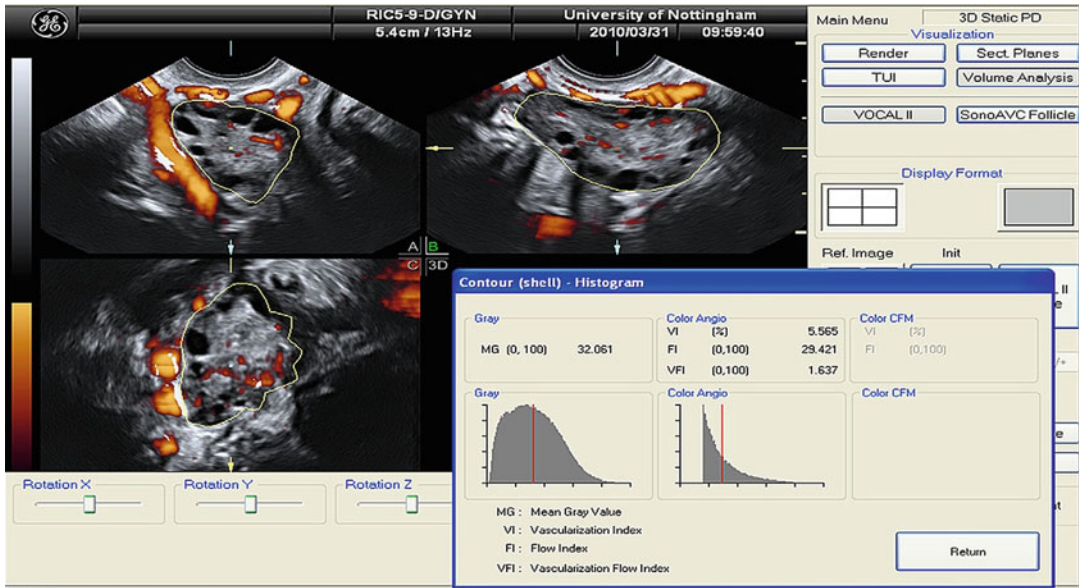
Mean gray value (MG) and 3D power Doppler indices within the ovarian volume delineated using VOCAL (Reprinted from Deb et al. [89]. With permission from Elsevier)
